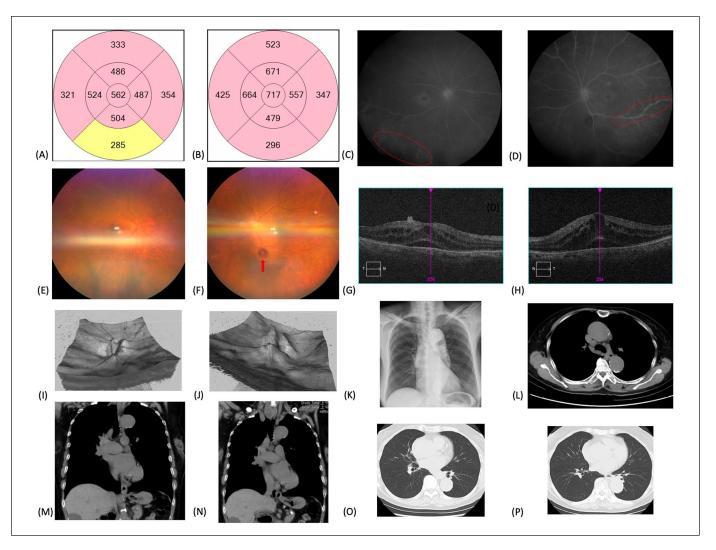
Initial findings in an 82-year-old woman presenting with blurred vision. Central subfield thickness was measured on optical coherence tomography (OCT) using a macular cube for (A) the right eye and (B) the left eye by evaluating the distance between the internal limiting membrane and retinal pigment epithelium. (C) Fluorescein angiography indicates mild capillary dilation and petaloid leakage in the foveal region with chorioretinal peripheral lesions (red circle) in the right eye, and (D) a similar pattern with segmental periphlebitis (red circle) is seen in the left eye. (E) Color fundus photography shows whitish retinal lesions in the midperiphery and swollen optic discs bilaterally, possibly attributable to granulomatous formation in the right eye. (F) A similar pattern with a macroaneurysm (red arrow) is seen in the left eye. (G) OCT scan of the right macula shows findings suggestive of subretinal fluid accumulation as well as intraretinal cysts, which were even more apparent in (H) the left eye. A 3-dimensional visualization of the optic disc cube shows nodules on the optic discs in (I) the right eye and (J) the left eye. (K) Increased lung markings are shown bilaterally on chest x-ray. (L and M) Chest computed tomography shows enlarged lymph nodes in the right paratracheal subaortic region and right hilar region. (N) A 2.7 cm lymph node is located in the right lower paratracheal region and a 4.5 cm heterogeneous mass in the right thyroid, with indentation on the trachea. In addition, tiny ground-glass opacities and nodules are observed in (O) the left lung and (P) the right lung.
